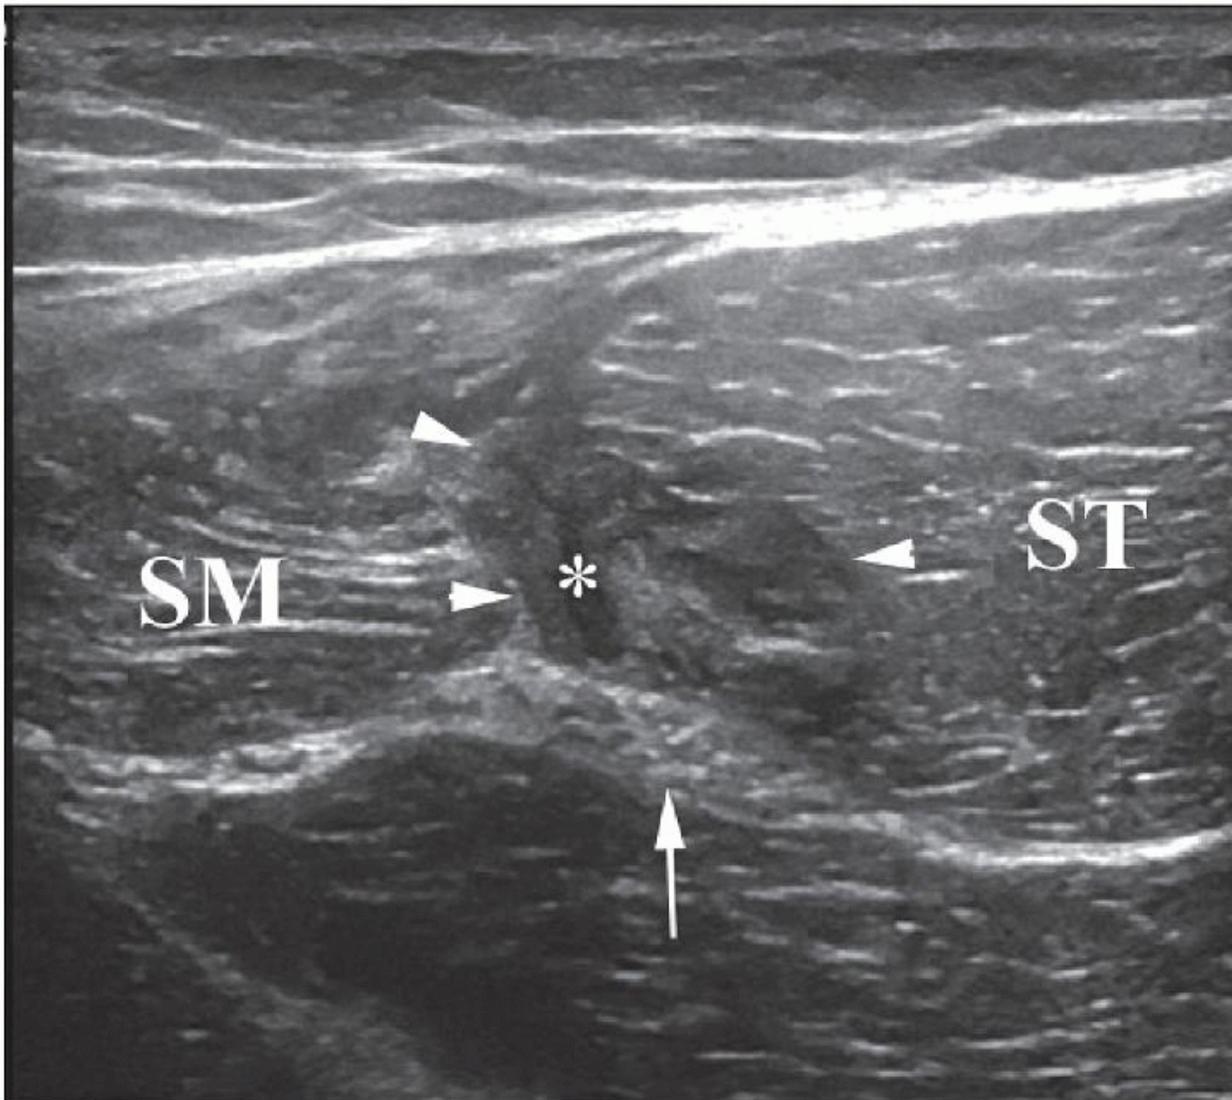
Acute hamstring injury. Transverse sonogram shows grade 2 tear (arrowheads) and hematoma (asterisk) in semitendinosus (ST) at margin with semimembranosus (SM) pushing on sciatic nerve (arrow). The exact nature of the pathology is not fully understood, but commonly seen changes are those of tendinopathy, including thickening, hypoechoogenicity, loss of fibrillar pattern, and sometimes calcification<sup>39</sup> (Fig. 6.23A). Partial thickness and full thickness tears are rare and tend to occur in elderly patients, especially following hip replacement surgery (Fig. 6.23B).
